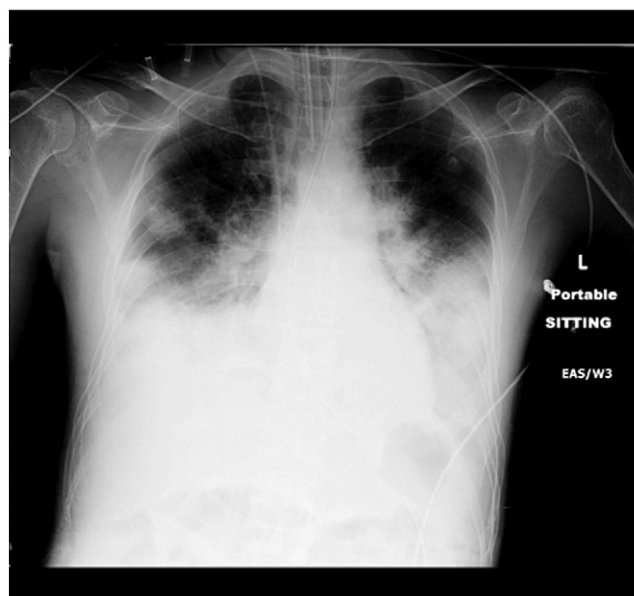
Chest radiography showing bilateral infiltrates consistent with pulmonary edema.
